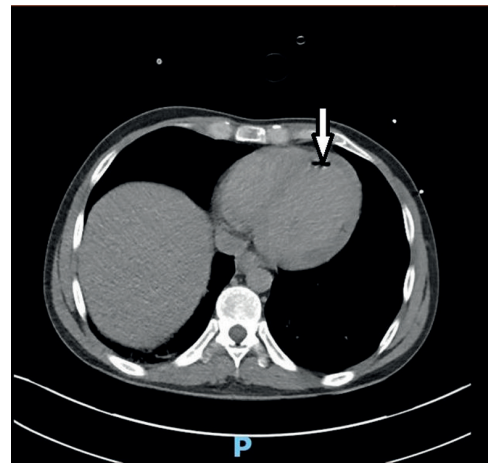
Computed tomography scan of the thorax showing air in the left ventricle (arrow).
